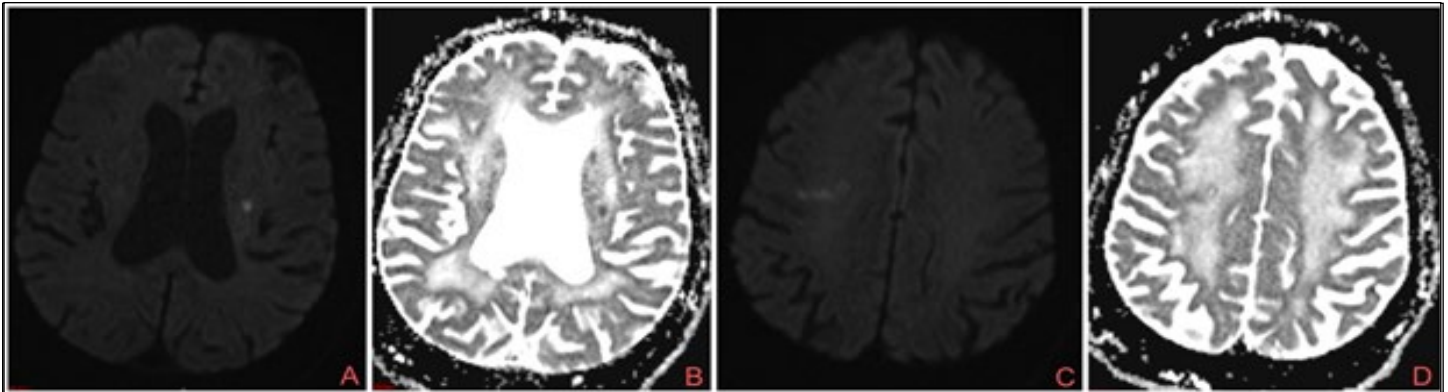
MRI brain diffusion and ADC images demonstrating bilateral acute strokes in the left corona radiata (A and B) and right centrum semiovale (C and D).
